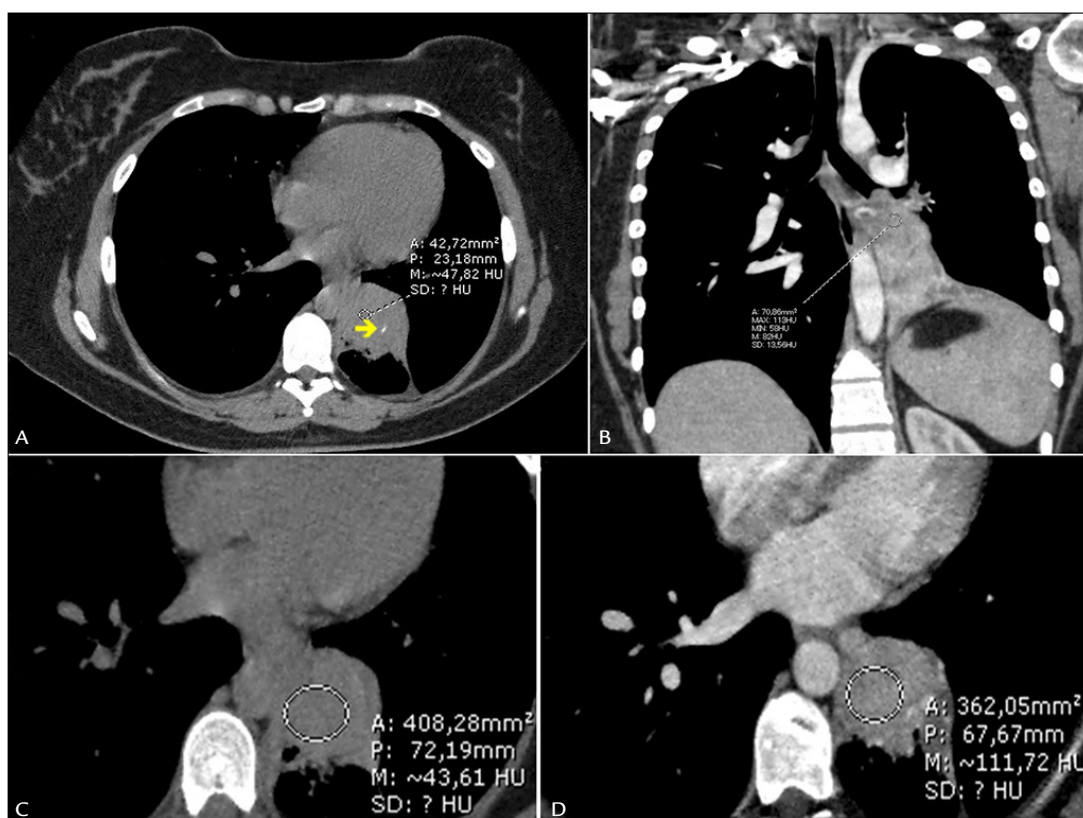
Computed tomography scan of the thorax, mediastinal window, without contrast medium (A, C) and after administration of intravenous iodate contrast agent (B, D), revealing a left infrahilar lung mass causing subsegmentar atelectasis of the ipsilateral inferior lobe, with exophytic nodular component protruding into the lumen of the left main and lower subsegmental bronchi. We found scarce punctiform calcifications and diffuse linear foci (A, yellow arrow), as well as accentuated enhancement with contrast medium (B, D) in the extensive mass.
